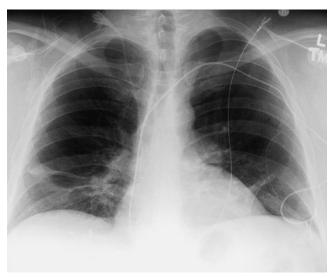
Plate Atelectasis. Posteroanterior chest x-ray shows linear areas of plate atelectasis in both lower lobes.
